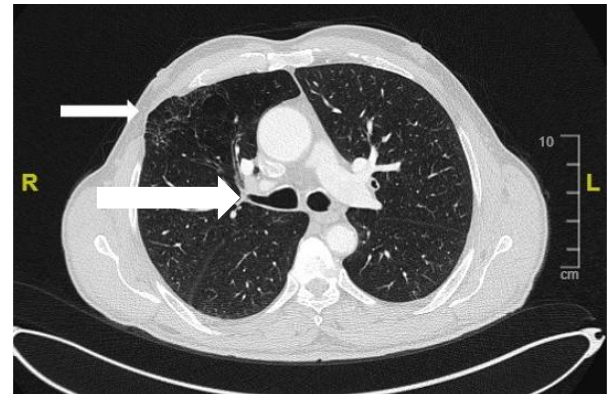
Chest CT revealed protrusion of a small part of the right upper lobe through the 4th intercostal space (white arrow)
